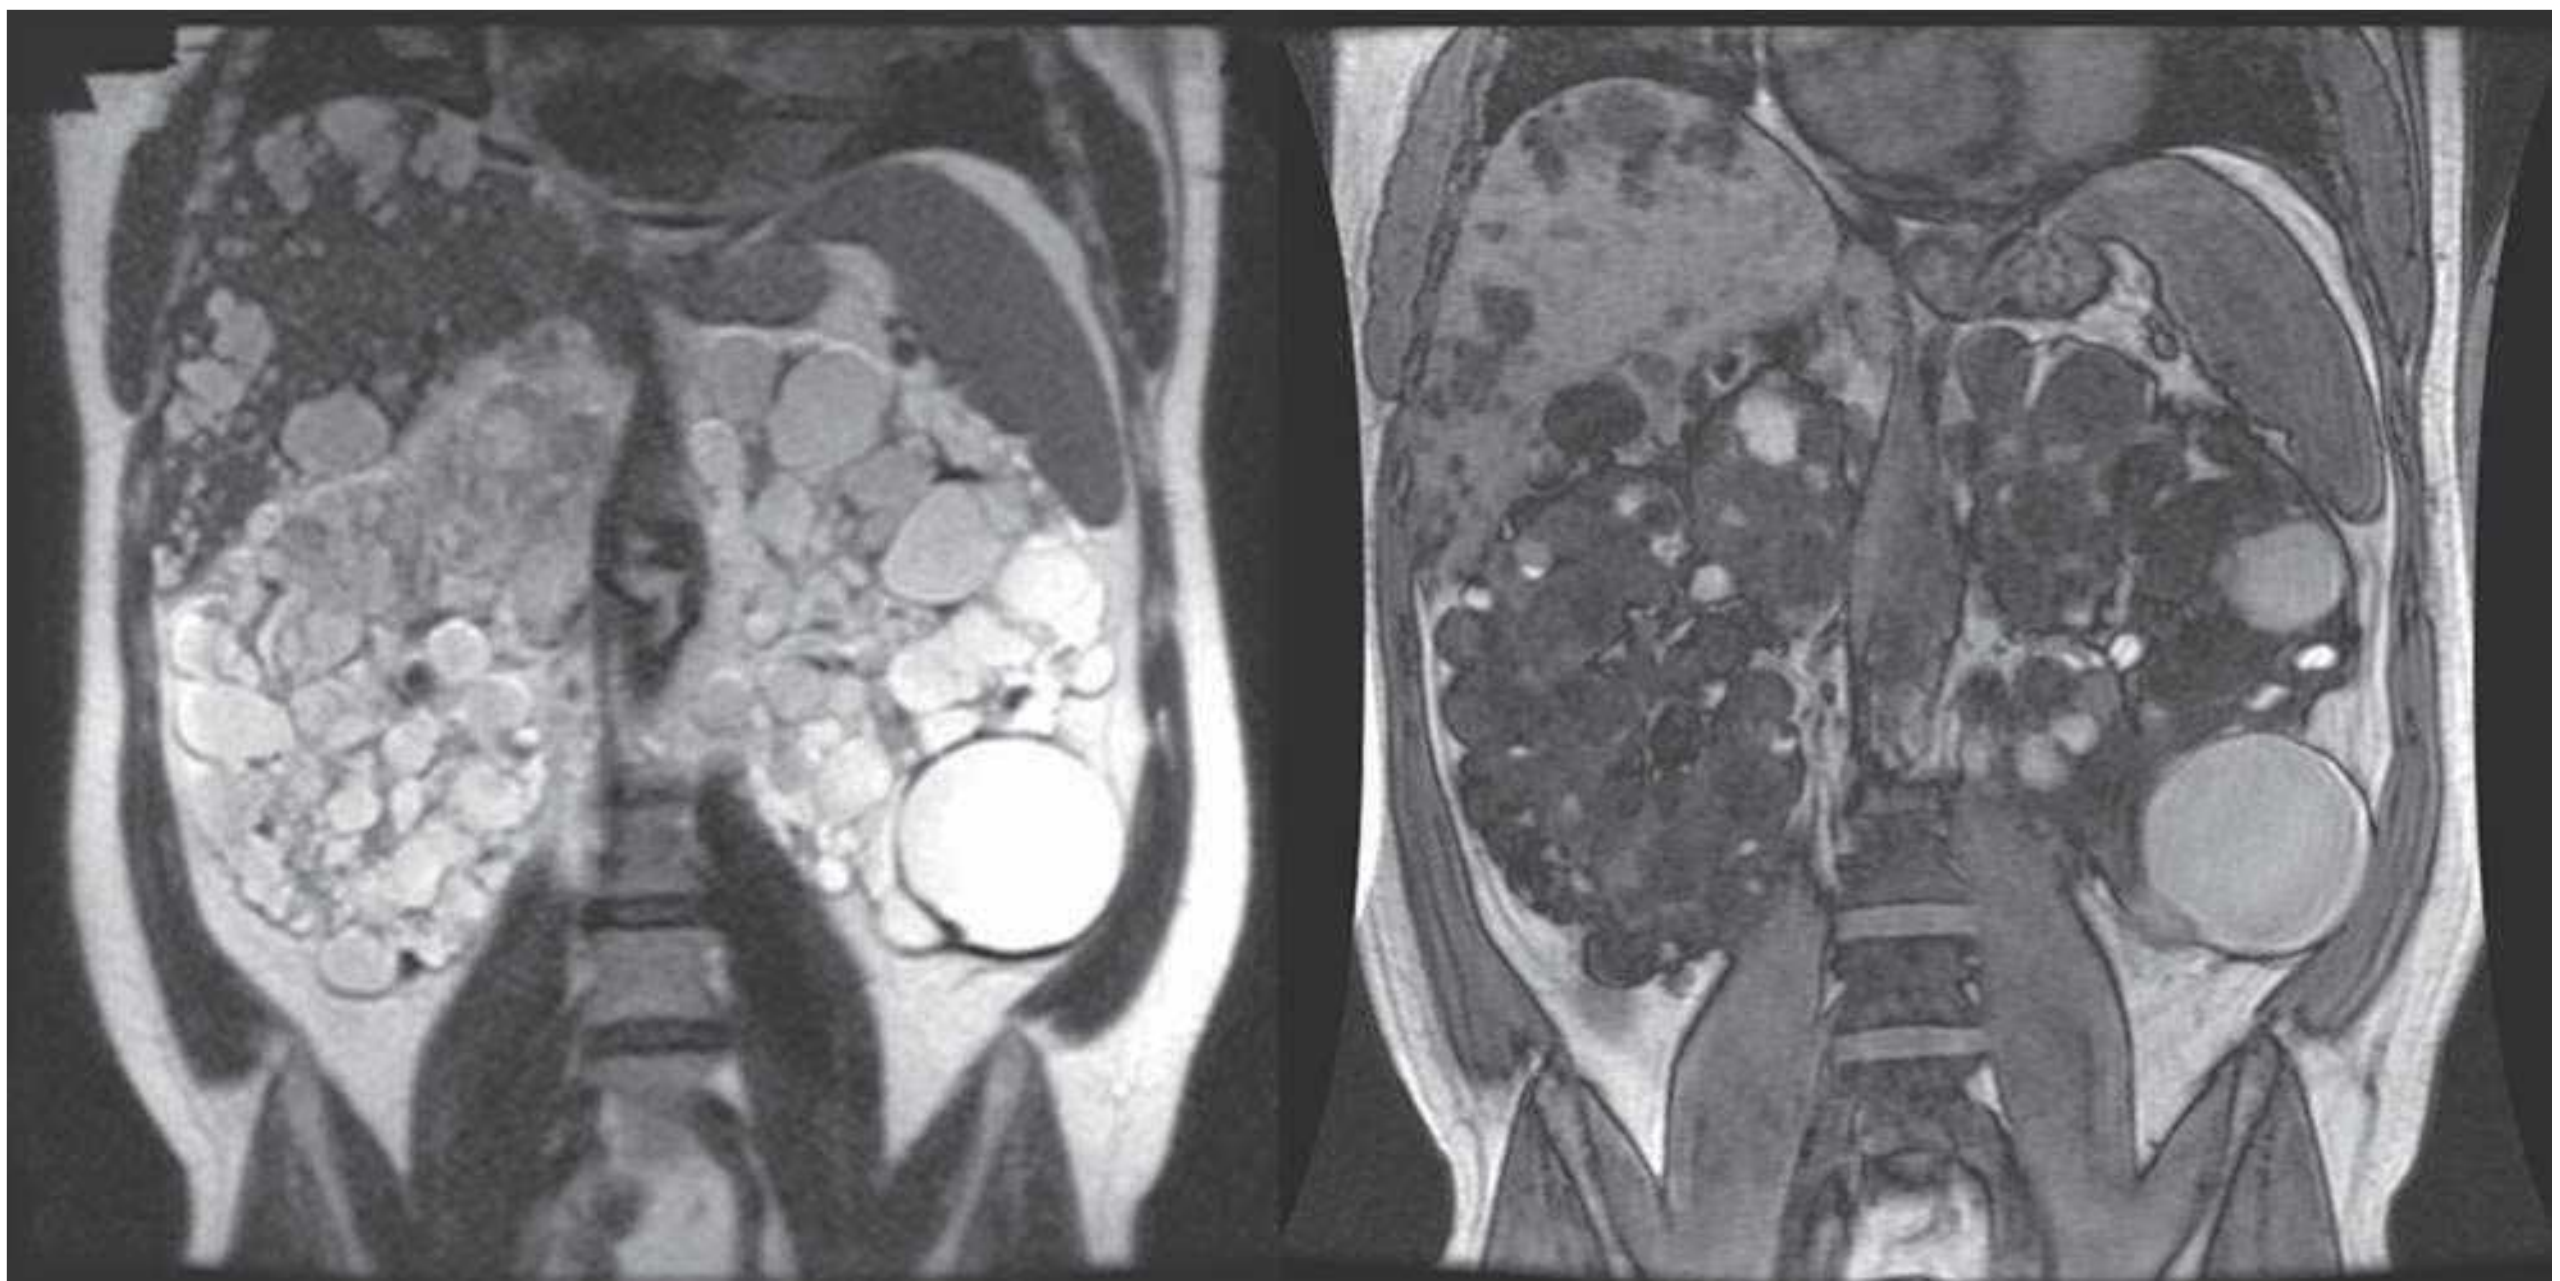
ADPKD on coronal MR images. Innumerable cysts occupying markedly enlarged bilateral kidneys on T2 (*left*) and T1 (*right*) MR images. Simple cysts are of bright T2 and dark T1 signal intensity, whereas complex cysts present with intermediate to bright T1 signal intensities. Extensive hepatic cysts are also present.
